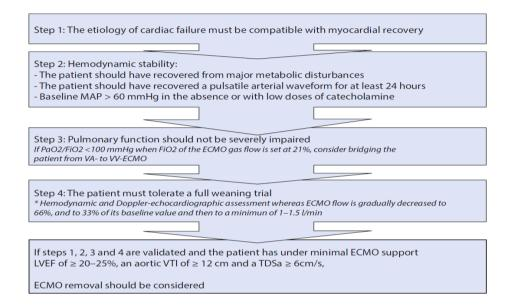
Recommendations for successful weaning from ECMO. Adapted from [41] with permission. MAP: mean arterial pressure; LVEF: Left ventricular ejection fraction; VTI: Velocity time interval; TDSa: tissue Doppler lateral mitral annulus peak systolic velocity
